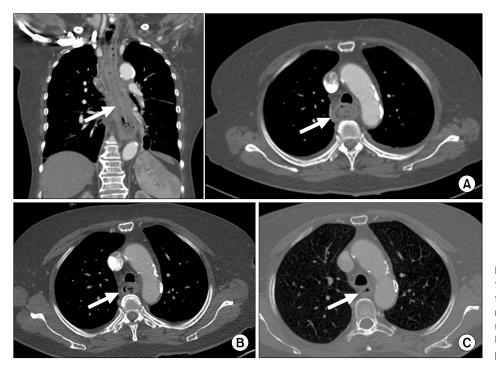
Chest CT images showing improvements in esophageal inflammation and disappearing submucosal areas of air density (arrow). (A) Initial CT. (B) 3 Weeks later. (C) 2 Months later. CT, computed tomography.
